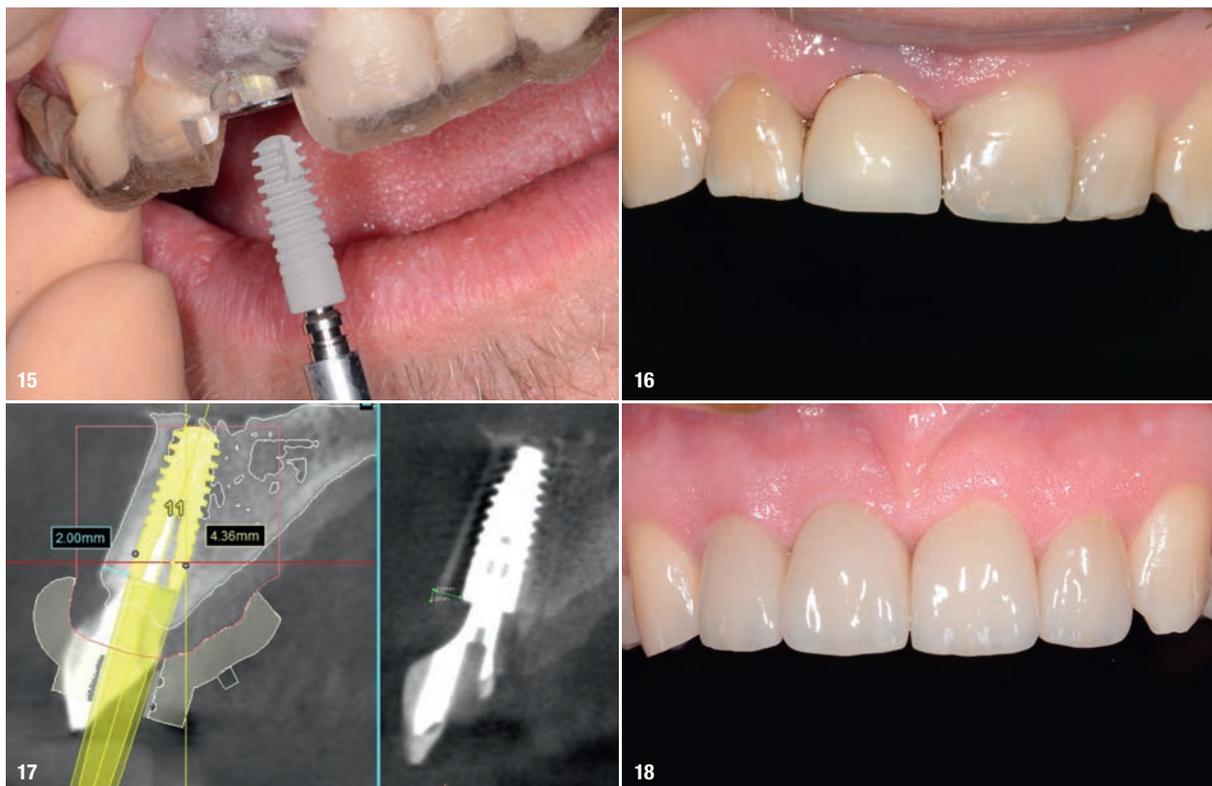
Placement of the Ankylos implant using the Siplant Guide. Fig. 16: Sub-crestal placement of the Ankylos implant. Attachment of the screw-retained IPS e.max crown on to the Atlantis abutment (non-functional restoration). Fig. 17: A follow-up CBCT scan demonstrated the perfectly executed positioning of the implant as it had been planned. Fig. 18: There was perfect adaptation of the soft tissue around the implant restoration. In addition, a ceramic crown was placed on tooth #12 (after root canal therapy) and ceramic veneers on teeth #21 and 22. Three years follow up shows stability of soft and hard tissue.
